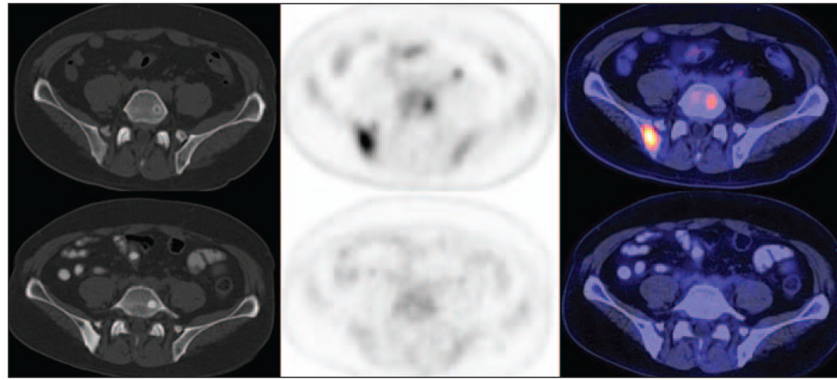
60-year-old man. CT (*left*), ¹⁸F-FDG PET (*middle*), and fused PET/CT (*right*) images show how androgen deprivation therapy induced decline in FDG uptake in osseous metastatic sites in posterior right ilium and left L5, with concomitant increase in lesion sclerosis. Top panels are pretreatment scans (prostate-specific antigen [PSA] level, 67.4 ng/mL), and bottom panels are posttreatment scans (PSA level, 0.3 ng/mL).
